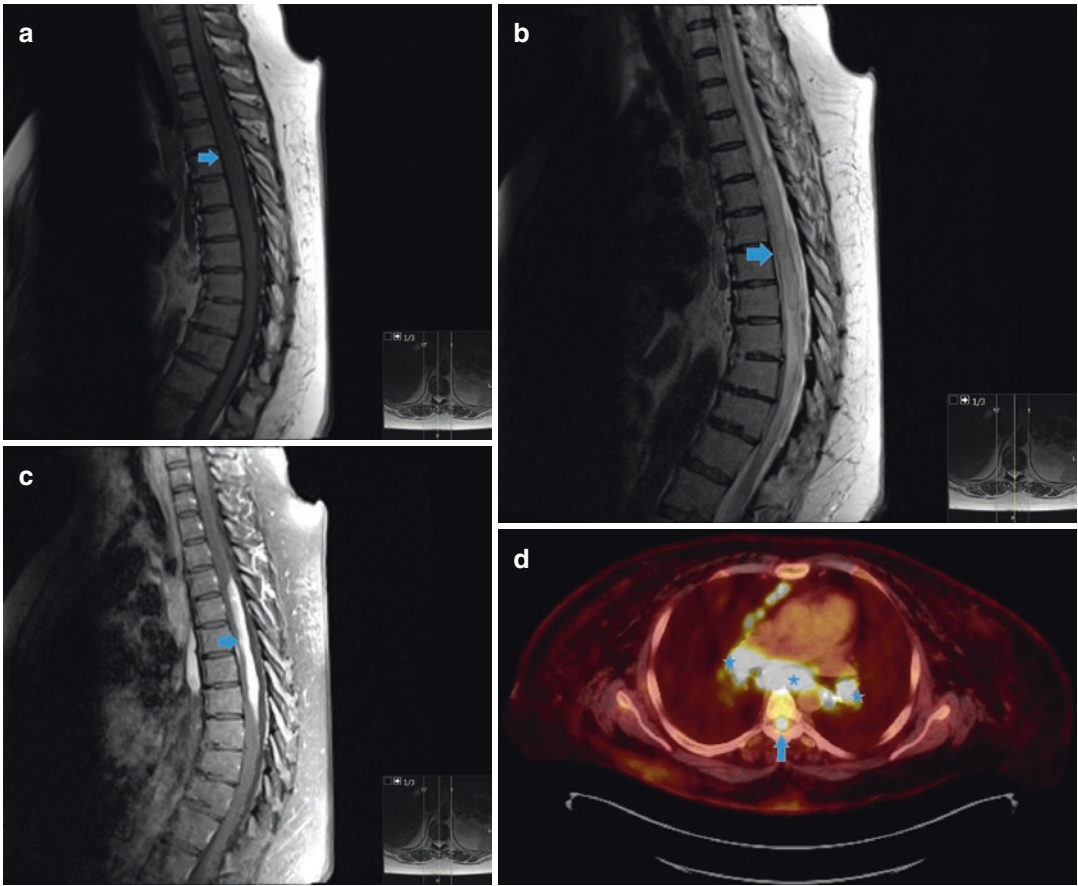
Intramedullary sarcoidosis. Figure 9.14a is a sagittal T1-weighted MR image showing mild expansion of the thoracic cord, with mild low T1 signal change within the cord (arrow). On the sagittal T2-weighted image (Fig. 9.14b), there is long-segment diffuse edema-like signal within the mildly expanded cord (arrow). The
